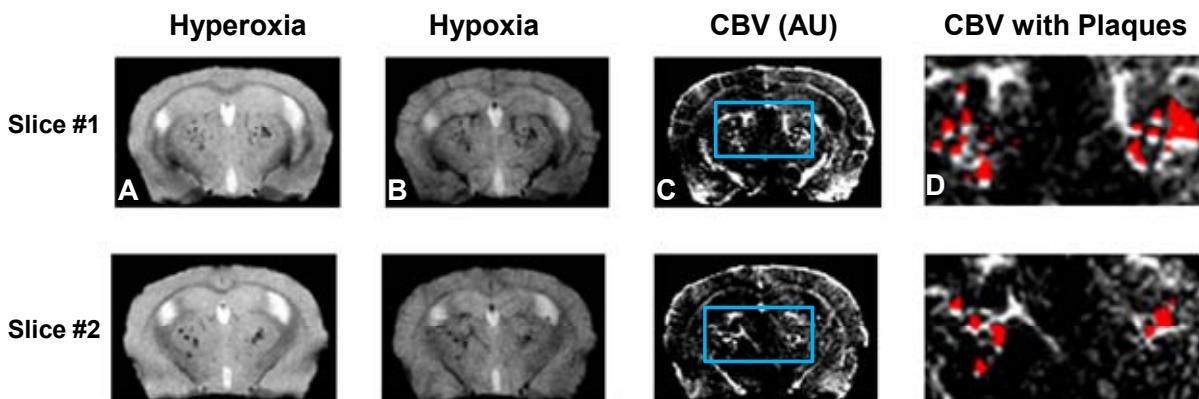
Two sample slices of MRI of AD associated angiogenesis. A and B show T₂* weighted images acquired at hyperoxia (100% O₂) and hypoxia (8% O₂) respectively. CBV map (C) constructed based on the ratio of image A and B shows cerebral vasculature. D shows the magnified CBV map from the selected region (highlighted in C). AD plaques are overlaid as red dots on the CBV map.
